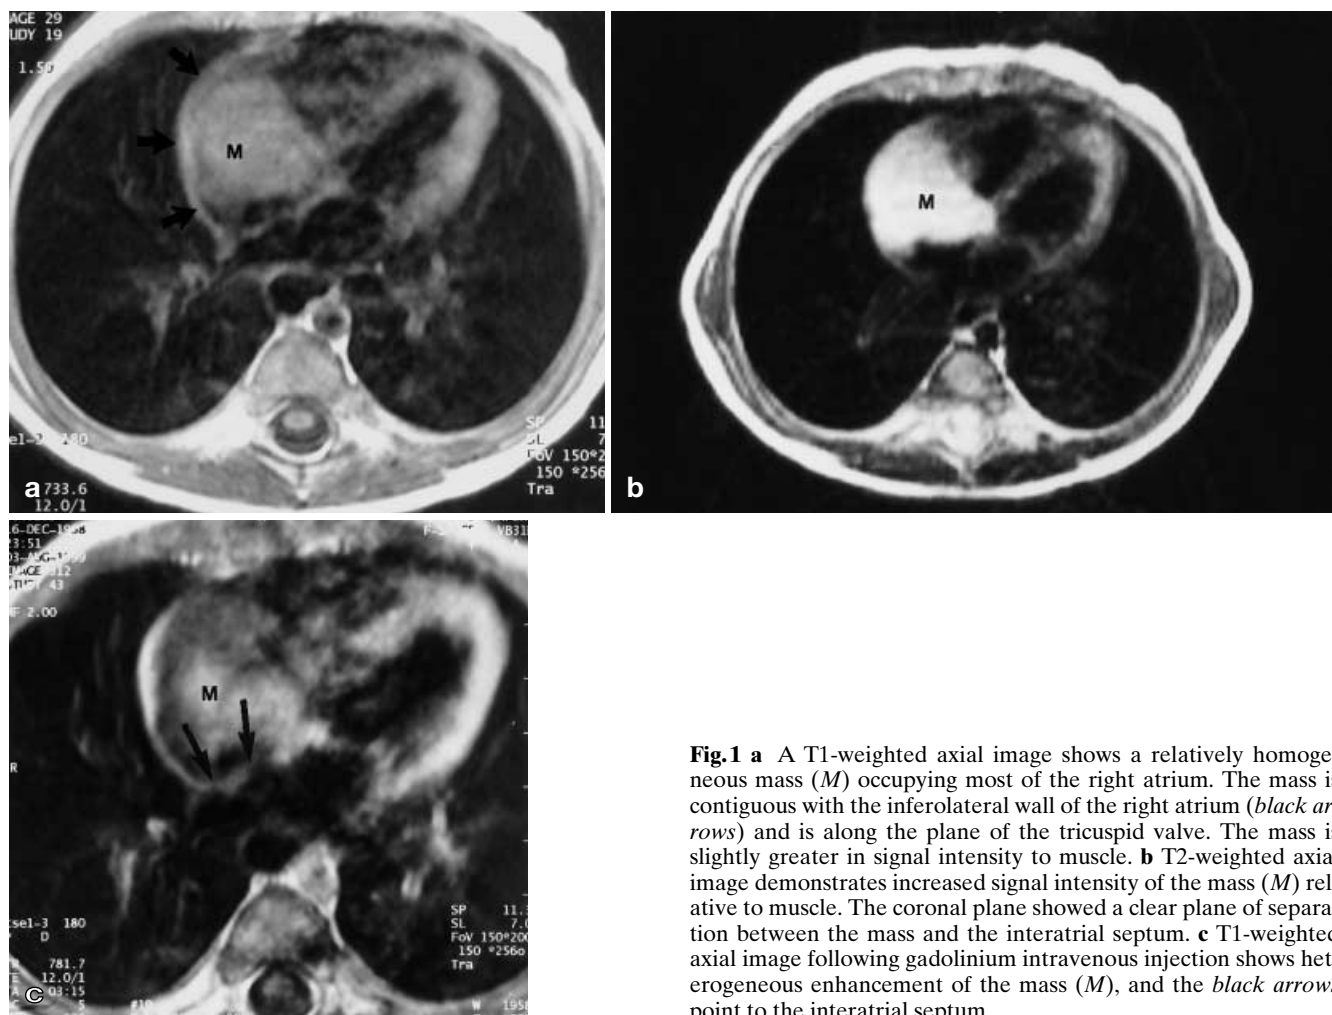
a A T1-weighted axial image shows a relatively homogeneous mass (*M*) occupying most of the right atrium. The mass is contiguous with the inferolateral wall of the right atrium (*black arrows*) and is along the plane of the tricuspid valve. The mass is slightly greater in signal intensity to muscle. b T2-weighted axial image demonstrates increased signal intensity of the mass (*M*) relative to muscle. The coronal plane showed a clear plane of separation between the mass and the interatrial septum. c T1-weighted axial image following gadolinium intravenous injection shows heterogeneous enhancement of the mass (*M*), and the *black arrows* point to the interatrial septum
